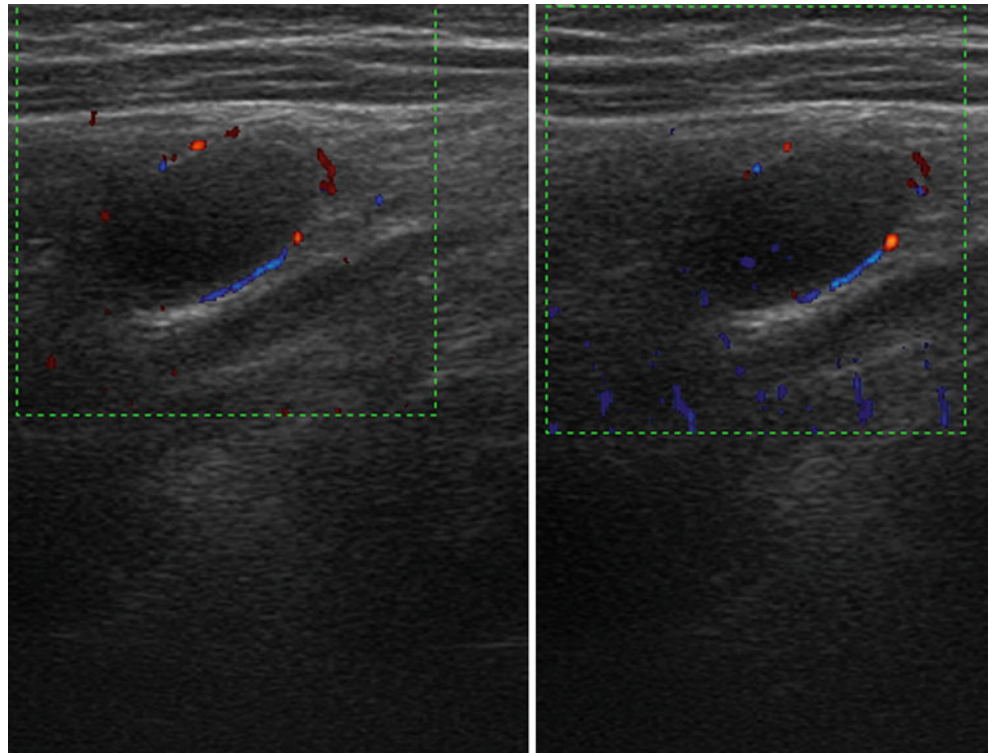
Lymph-node metastasis. Heterogeneously hypoechoic inguinal lymph node (27×11 mm, a) with multiple peripheral flow signals on directional power Doppler imaging (b)
